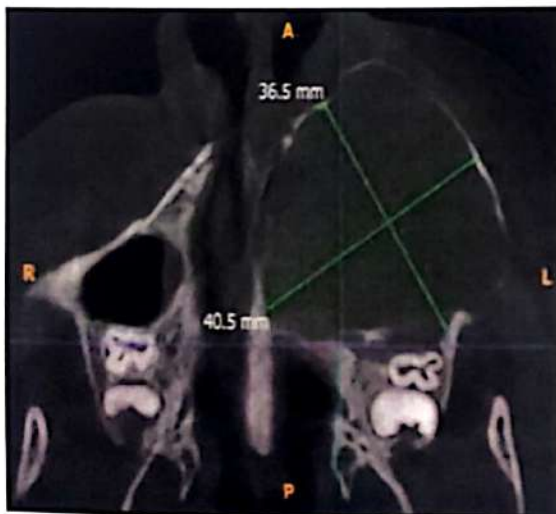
Dimensions on CBCT on axial section
